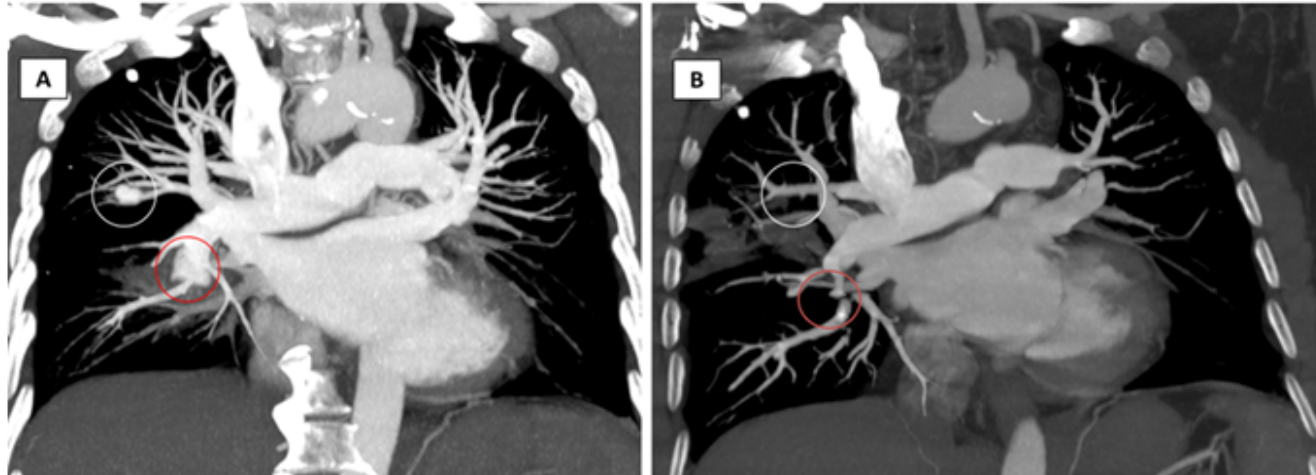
Coronal maximum intensity projection (MIP) CT contrast enhanced angiography images of the chest.
